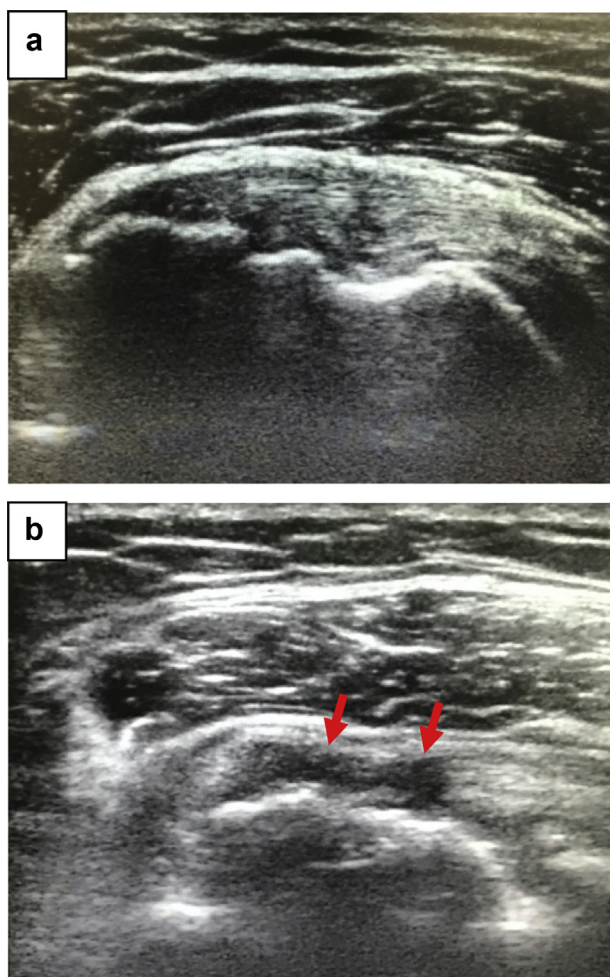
Postoperative ultrasonography of the subscapularis tendon (Left shoulder). (a) Successful repair; (b) Torn subscapularis tendon (✗).
